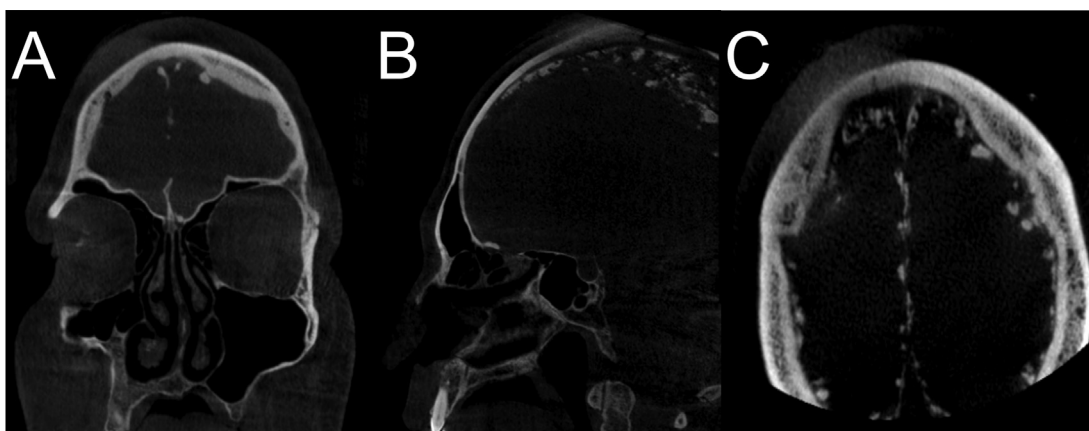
CBCT coronal (A), sagittal (B), axial (C) slices of a patient with NBCSS. Note the falx cerebri calcifications at all slices.
